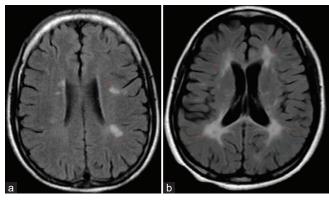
(a and b) Magnetic resonance imaging T2-weighted (fluid-attenuated inversion recovery) axial view showing multiple hyperintense lesions predominant in white matter, callosal, and pericallosal region in frontal, parietal, and temporal lobe
